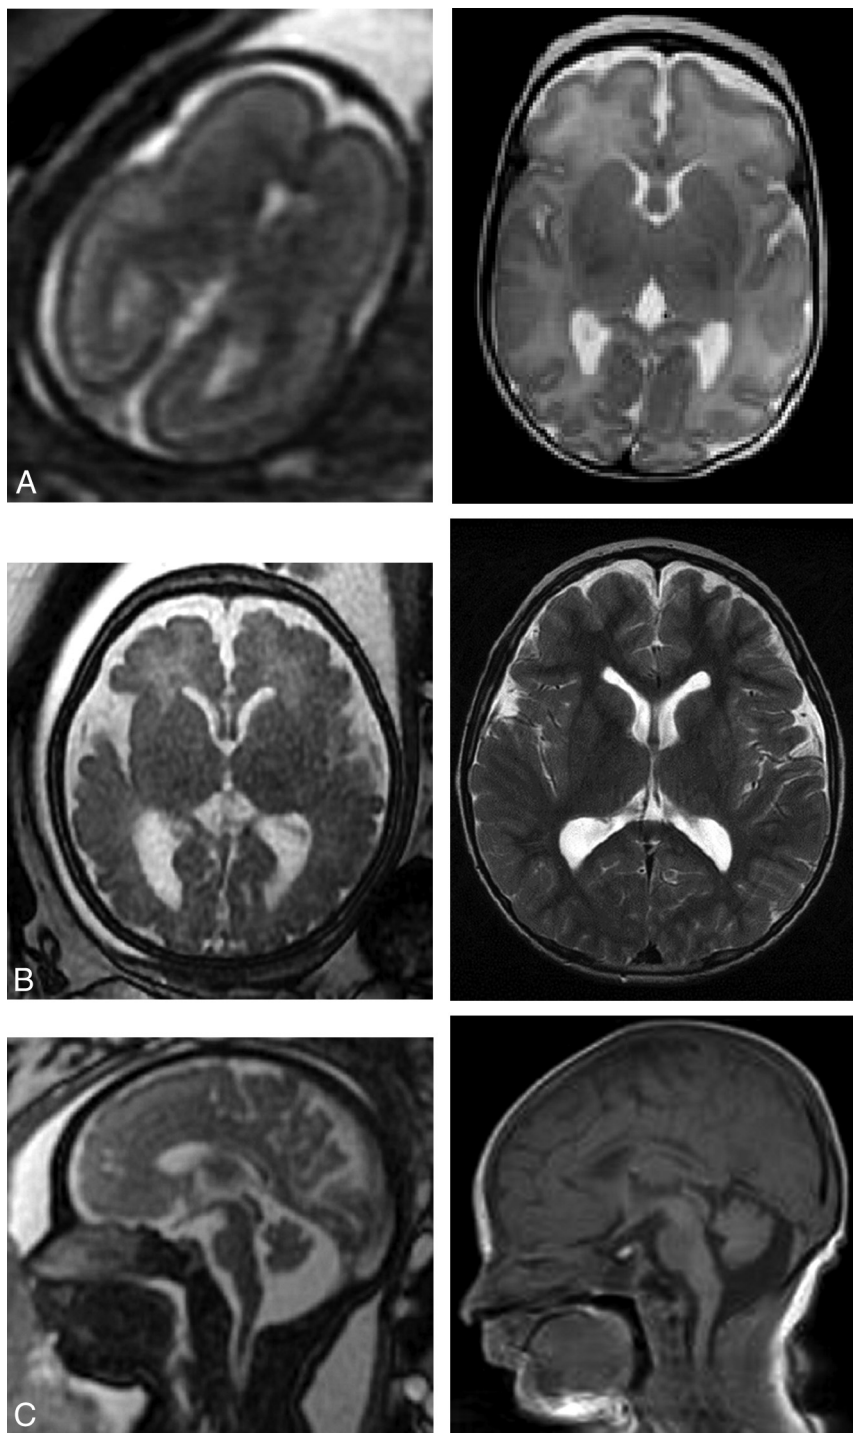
Prenatal and postnatal imaging examples of cases in which an indeterminate prognosis was associated with a favorable outcome. A, Axial single-shot fast spin-echo at 23 weeks with primitive sulcation and oligohydramnios. Axial T2 at 2 months of age shows normal brain MRI findings. B, Axial single-shot fast spin-echo at 35 weeks with VM (left 13 and right 12 mm). MRI at 6 years of age shows persistent prominent VM similar to findings on the ultrasound after birth (not shown). The patient has normal neurologic examination findings. C, Sagittal single-shot fast spin-echo at 35 weeks with a large cisterna magna versus vermian hypoplasia. Sagittal T1 at 3 days of life shows a prominent cisterna magna without other abnormalities.
